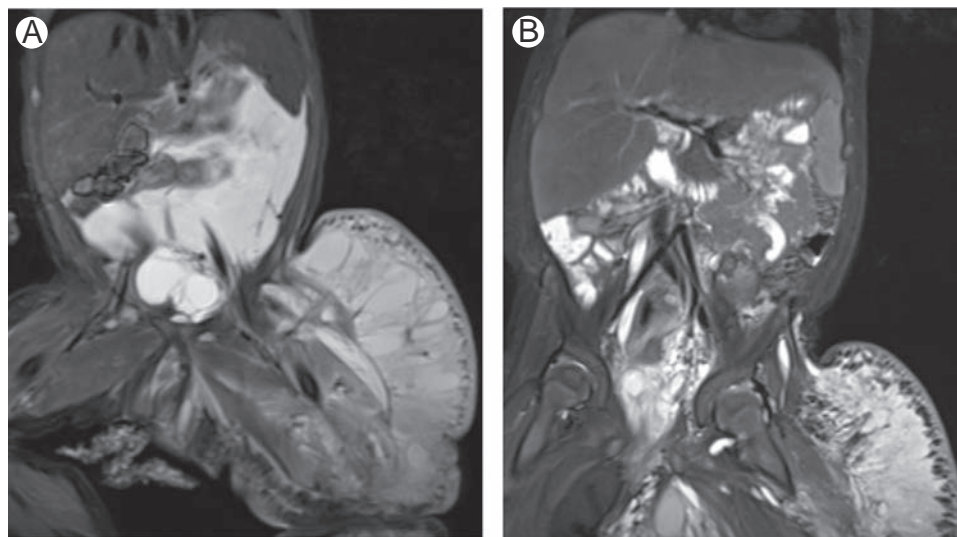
Rapamycin treatment. (A) T2-weighted MRI of a 3-week-old female with extensive LM involving the left lower extremity and abdomen. Owing to the extensive nature, the lesion was treated with rapamycin alone. (B) T2-weighted MRI obtained 9 months after treatment shows near resolution of the intra-abdominal component and decrease in size of the microcystic soft tissue components.
